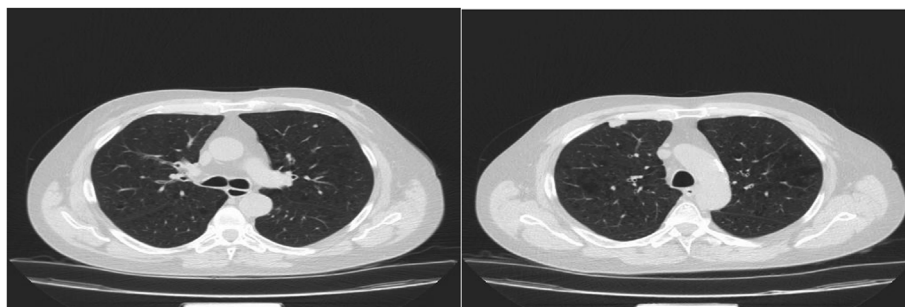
HRCT of case 2 showed bilateral apical scarring; several non-calcified lung nodules of different sizes were noted bilaterally. The largest is sub pleural indeterminate nodule/plaque of right upper zone.
